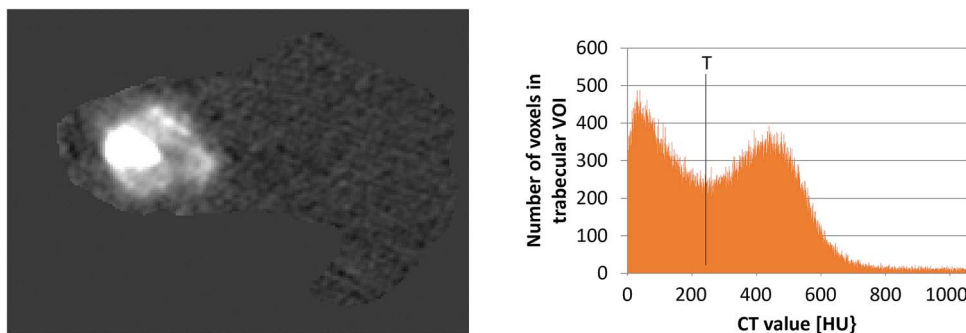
Segmentation of the AGN_i VOI in 12-wk scans. The axial view (left) shows the difference of the trabecular VOI between pre- and post-injection. At locations without AGN1 injection, the difference is small resulting in the noisy pattern. The injected AGN1 gives a much larger contrast because there was no AGN1 in the pre-injected image. This contrast enhancement is used for segmentation of the AGN VOI. The graph on the right shows a CT value histogram of the complete trabecular VOI. A patient-specific threshold T1 (here T1 = 270 HU) was automatically determined using the minimum of the histogram to separate original trabecular BMD from injected AGN1 resulting in the segmentation of the AGN_i VOI shown in Figure 1. Abbreviations: HU, Hounsfield units; VOI, volume of interest; BMD, bone mineral density.
